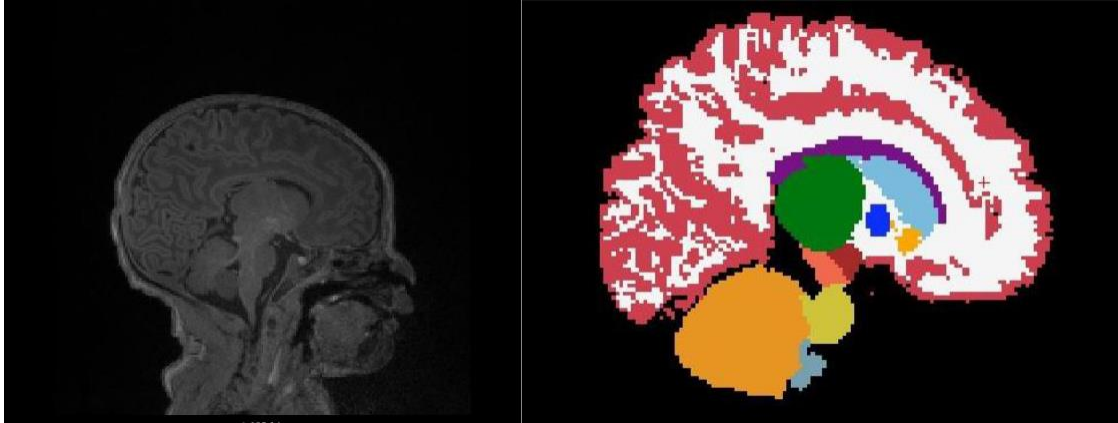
Sagittal view of T1- weighted Infant MRI before and after volumetric segmentation
